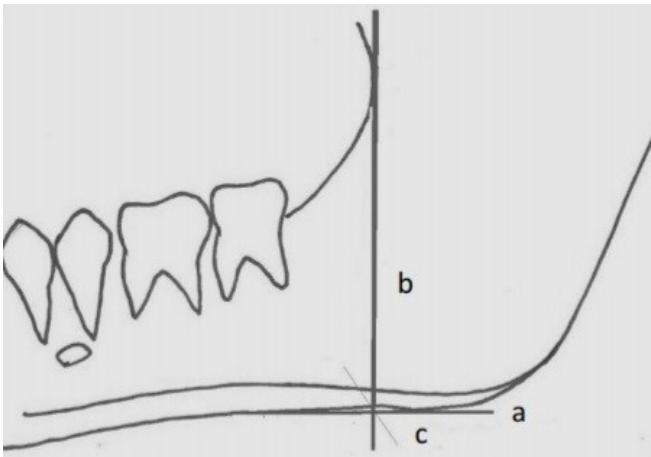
Measurements on the panoramic radiography for antegonial index.
